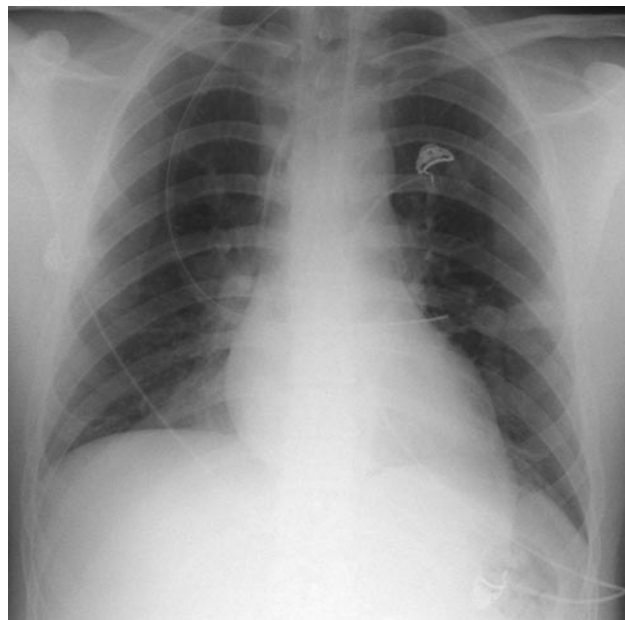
Bedside chest x-ray examination (day 4).
